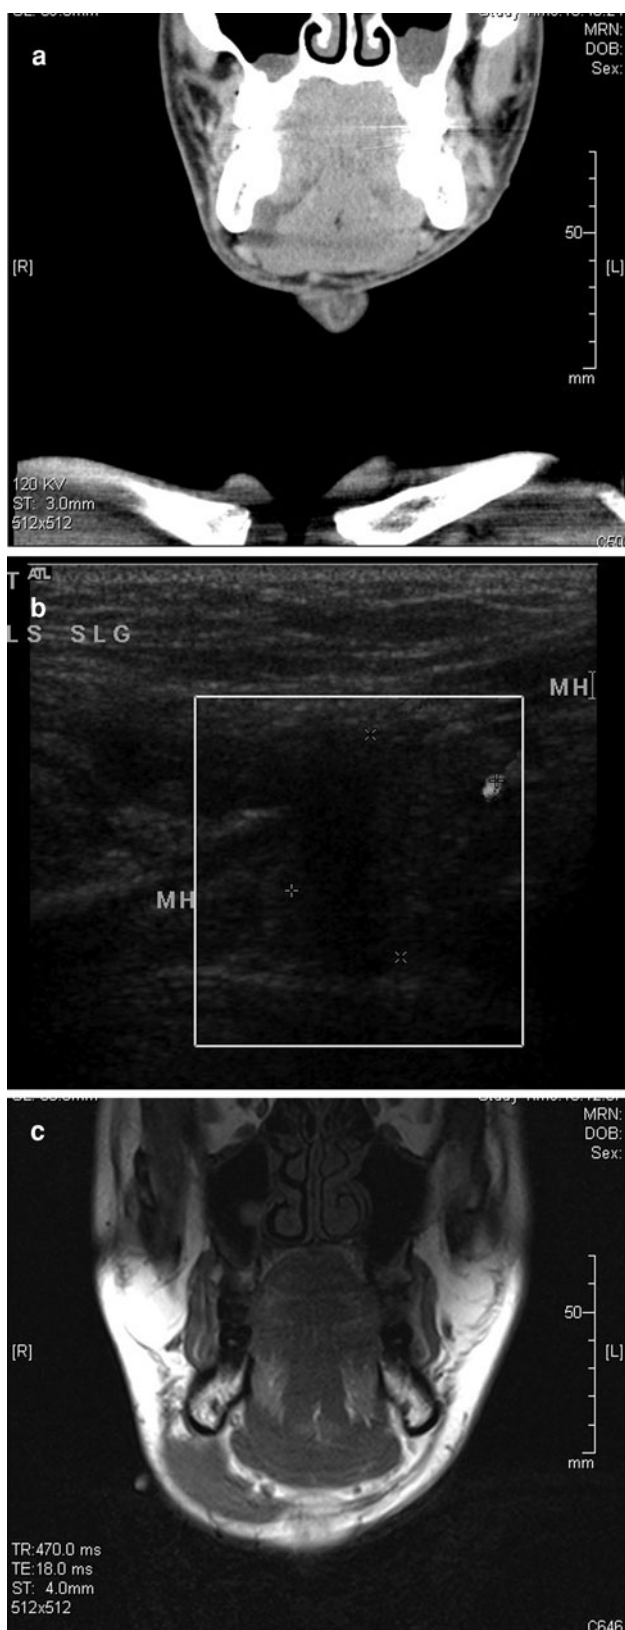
Pseudocyst with mylohyoid defect seen on (a) CT scan, (b) ultrasound, and (c) MRI
